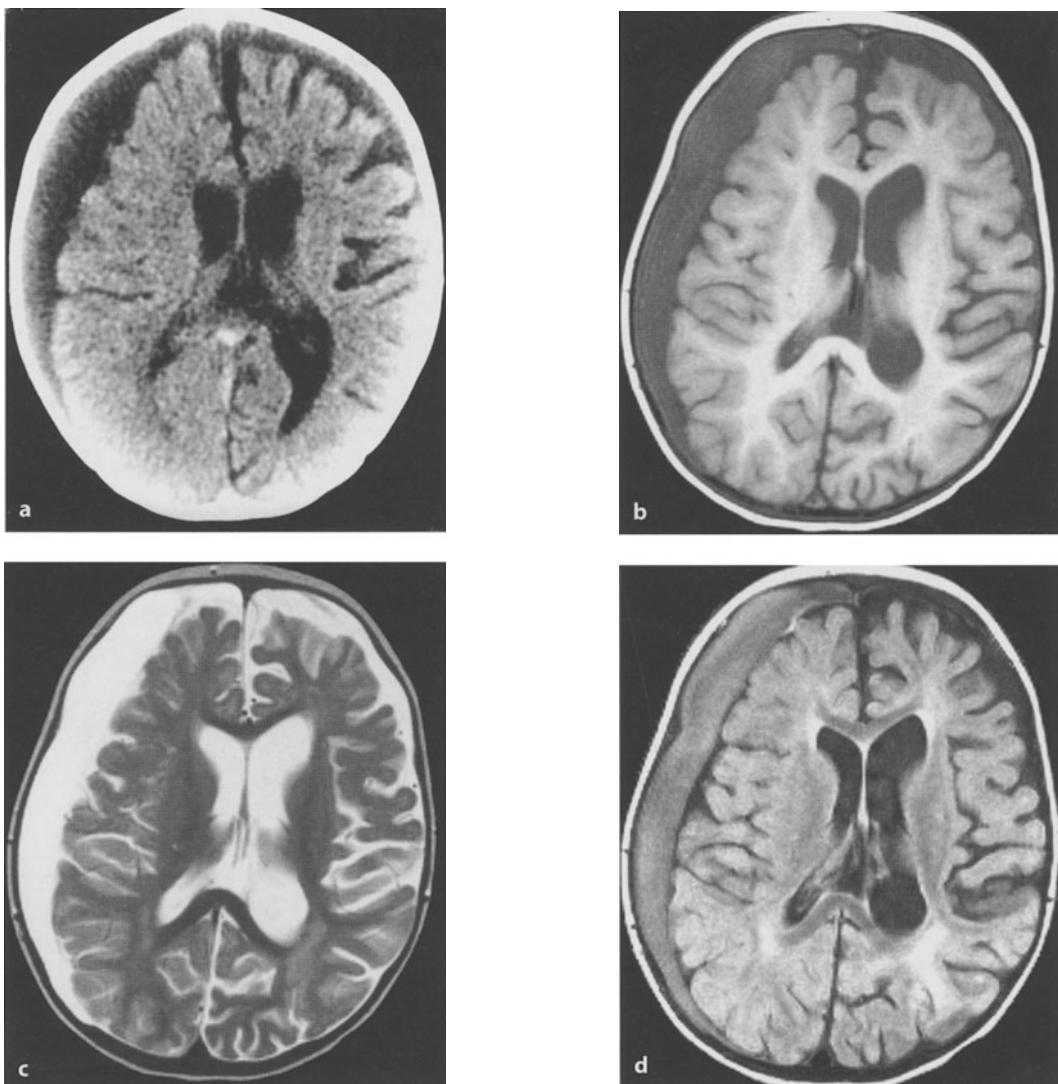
Subdural collections. a CT scan of a 10-month-old girl who had received anti-coagulation medication for heart surgery for several months. There is a collection overlying the convexity of the right hemisphere, compressing the underlying cortex. The signal is of mixed density. The ventricular cavities are slightly dilated. b T1-weighted MRI scan showing the right convexity collection. The signal intensity inside the collection is higher than that of the ventricular CSF. The collection does not enter the sulci but compresses them. The subarachnoid space appears separate underneath the collection, as a lower-intensity signal inside the sulci. On the left side the subarachnoid spaces are prominent over the frontal pole. c T2-weighted MRI scan, showing the right subdural collection. There are no signal-void blood vessels traversing the collection. In contrast, in the region of the left frontal pole there are vessels traversing the subarachnoid space, from the dura to the cortical surface. d Proton-density MRI scan, showing clearly the difference in signal intensity between the right subdural collection and the enlarged subarachnoid spaces on the left frontal region
